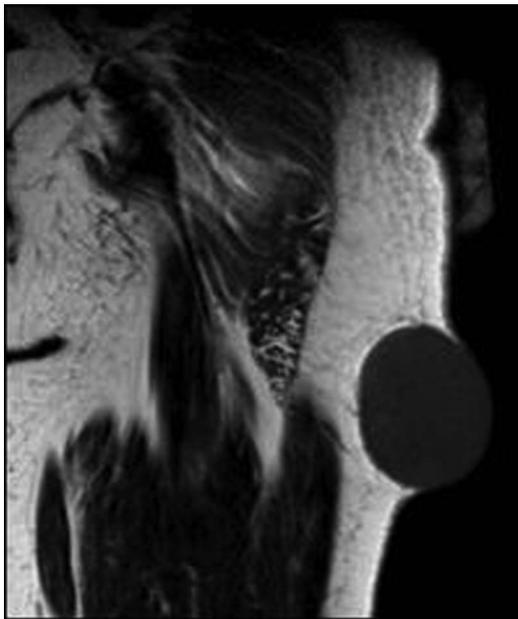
Coronal T1-weighted image, TR 650 ms TE 15 ms. Low signal intensity mass.
